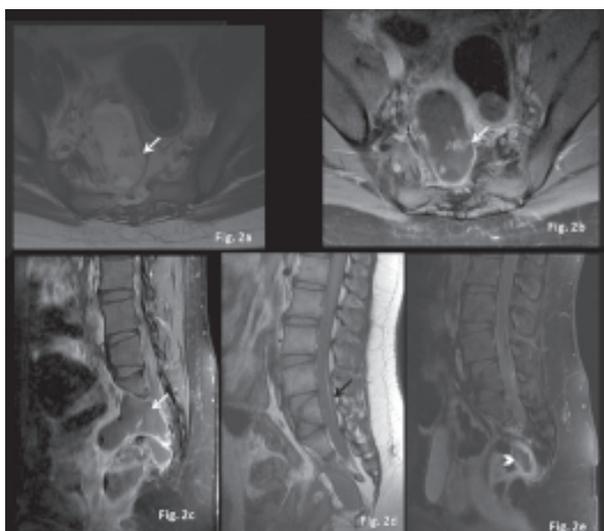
MRI T2 & T1 post contrast axial images showed a peripherally enhancing presacral cystic lesion with an intraspinal component (white arrow). Few air pockets noted within it. Diffuse spinal meningeal enhancement is also seen on contrast administration.
